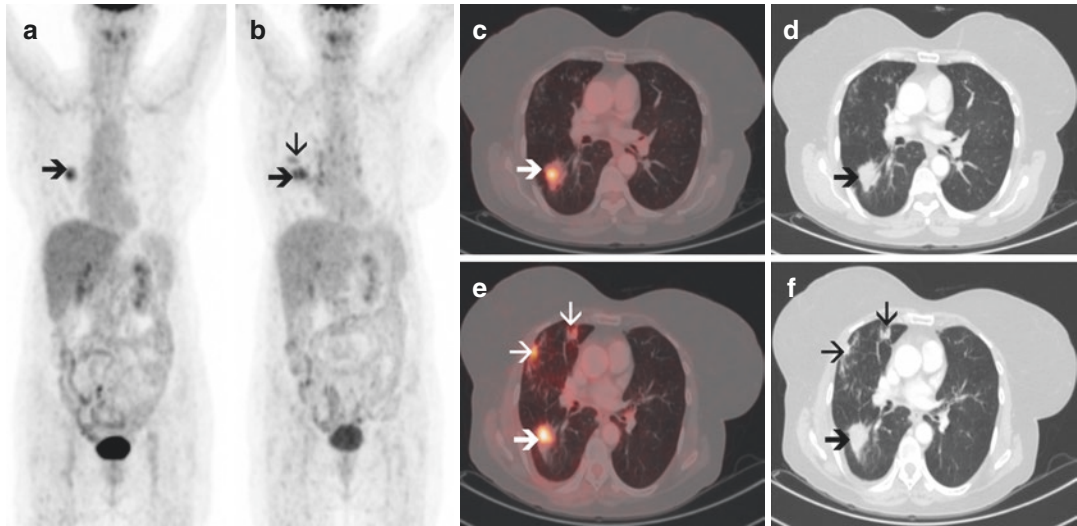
Lung cancer post neoadjuvant chemotherapy, showing partial response. Description: A 28-year-old lady with adenocarcinoma of left lung treated with neoadjuvant chemotherapy prior to surgical resection. Baseline whole-body MIP (a), axial fusion (c) and axial CT images (d) show a left lung mass (thick arrow). Post-therapy
